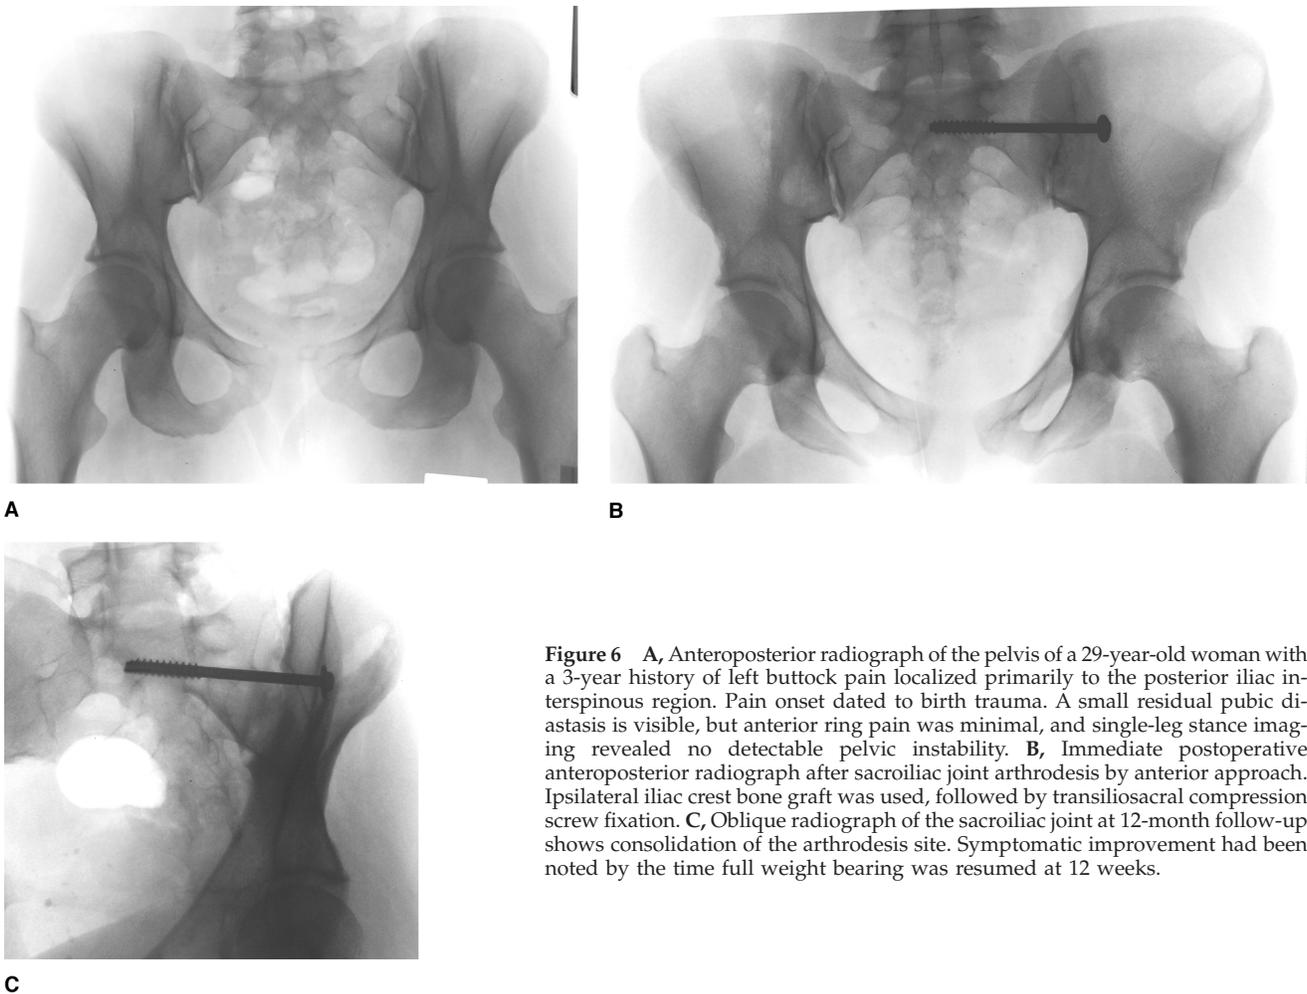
A, Anteroposterior radiograph of the pelvis of a 29-year-old woman with a 3-year history of left buttock pain localized primarily to the posterior iliac interspinous region. Pain onset dated to birth trauma. A small residual pubic diastasis is visible, but anterior ring pain was minimal, and single-leg stance imaging revealed no detectable pelvic instability. B, Immediate postoperative anteroposterior radiograph after sacroiliac joint arthrodesis by anterior approach. Ipsilateral iliac crest bone graft was used, followed by transiliosacral compression screw fixation. C, Oblique radiograph of the sacroiliac joint at 12-month follow-up shows consolidation of the arthrodesis site. Symptomatic improvement had been noted by the time full weight bearing was resumed at 12 weeks.
